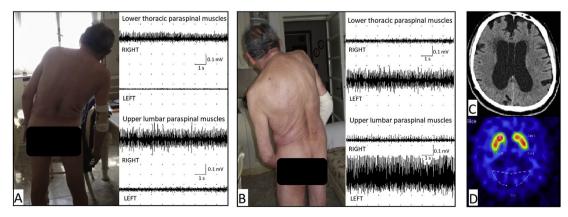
iNPH patient with "Metronome" Pisa syndrome.A-B Two-channels needle EMG recording of lower thoracic paraspinal muscles (top panel) and upper lumbar paraspinal muscles (bottom panel), showing right hyperactivity when bending rightward (A) and left hyperactivity when bending leftward (B) (hyperactivity of trunk muscles ipsilateral to the bending side). C Axial CT scan, displaying dilated lateral ventricles (Evans' index 0.45). D [123I]FP-CIT SPECT scan, showing preserved presynaptic nigrostriatal dopaminergic system.
